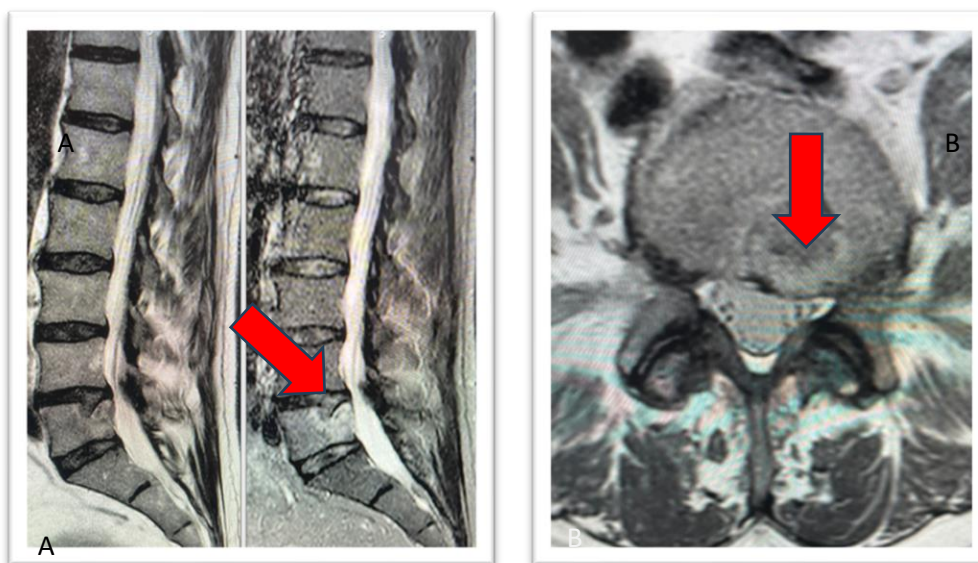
A-B: sagittal and axial MRI of the lumbosacral spine: an area of altered signal intensity involves the left hemibody of L5 (arrows).
